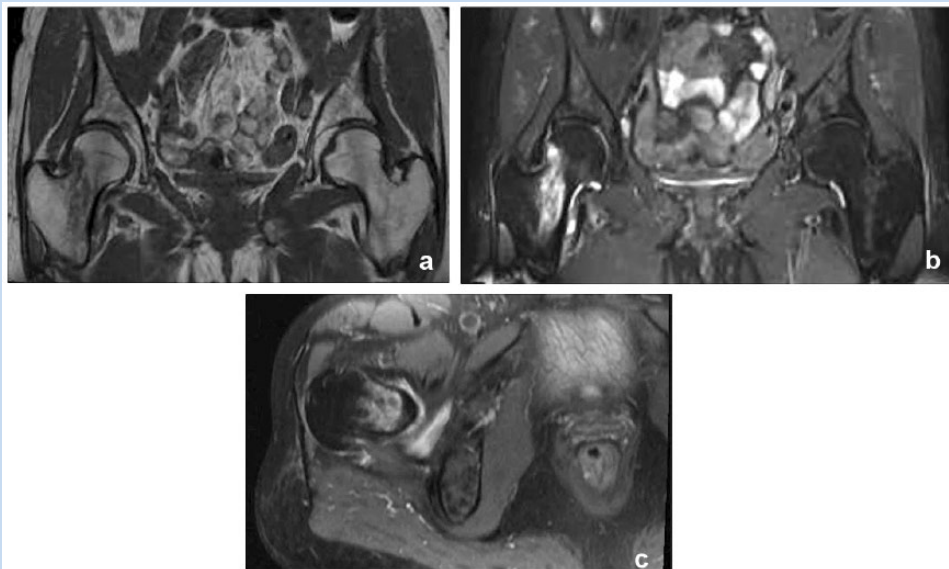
Bony changes from a stress fracture in the right femoral neck of a 62-year-old woman. (a) T1-weighted coronal magnetic resonance imaging (MRI). (b) T2-weighted coronal MRI. (c) T2-weighted axial MRI.
